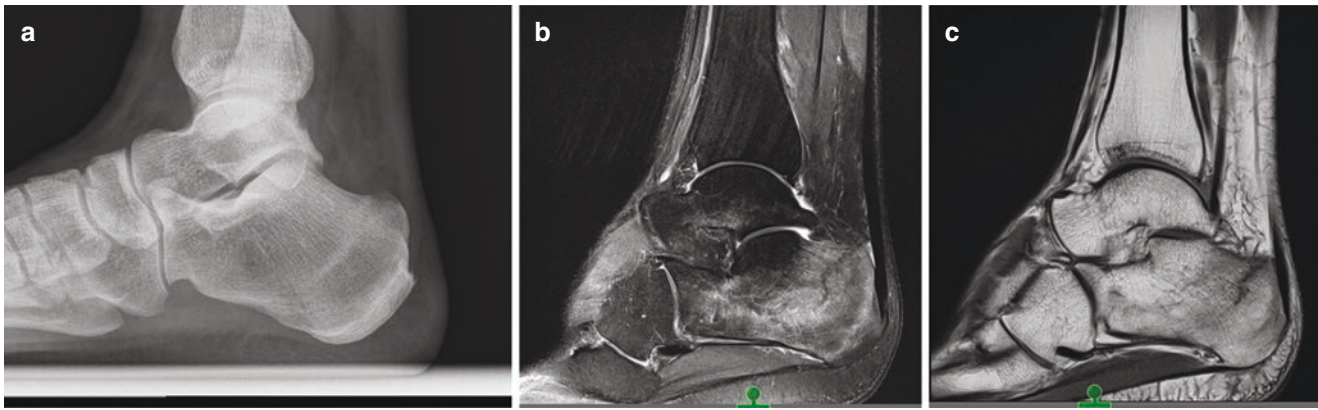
(a) Calcaneal stress fracture X-ray. (b) T2 MRI showing calcaneal stress fracture. (c) T1 MRI showing calcaneal stress fracture
